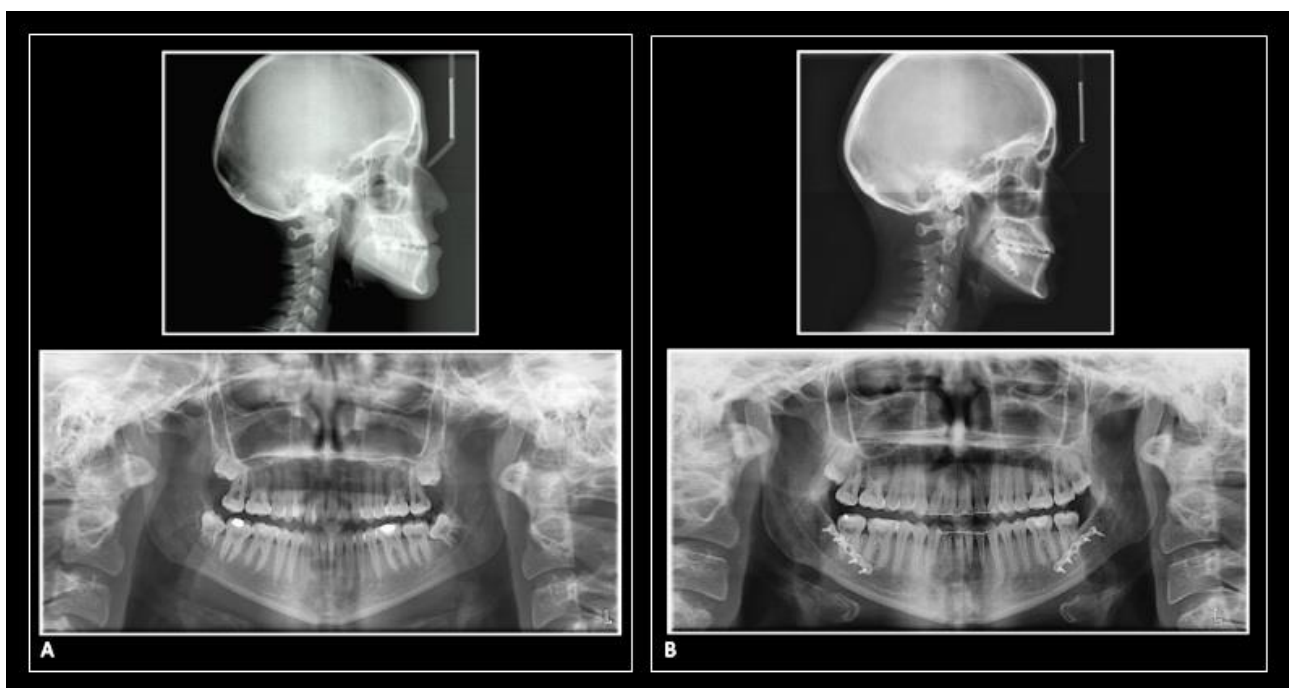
Pre- (A) and post-treatment (B) radiographs of Case 1.
